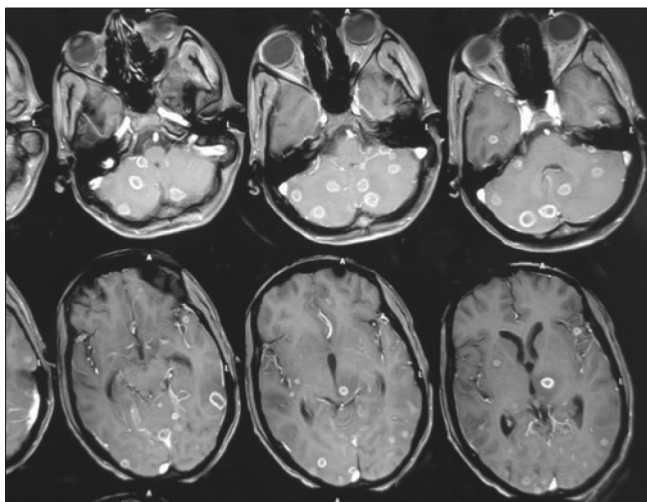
Magnetic resonance imaging brain contrast revealing multiple ring enhancing lesions in both cerebral hemisphere and cerebellum S/O tuberculoma
